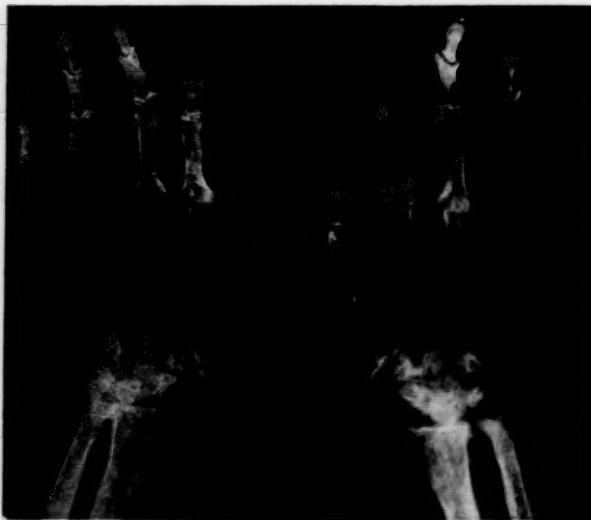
Roentgenogram of hands and wrists showing extensive joint destruction.
